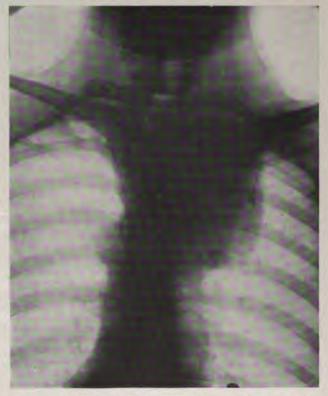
Differential diagnosis of intrathoracic goiter. Radiograph of intrathoracic goiter.
